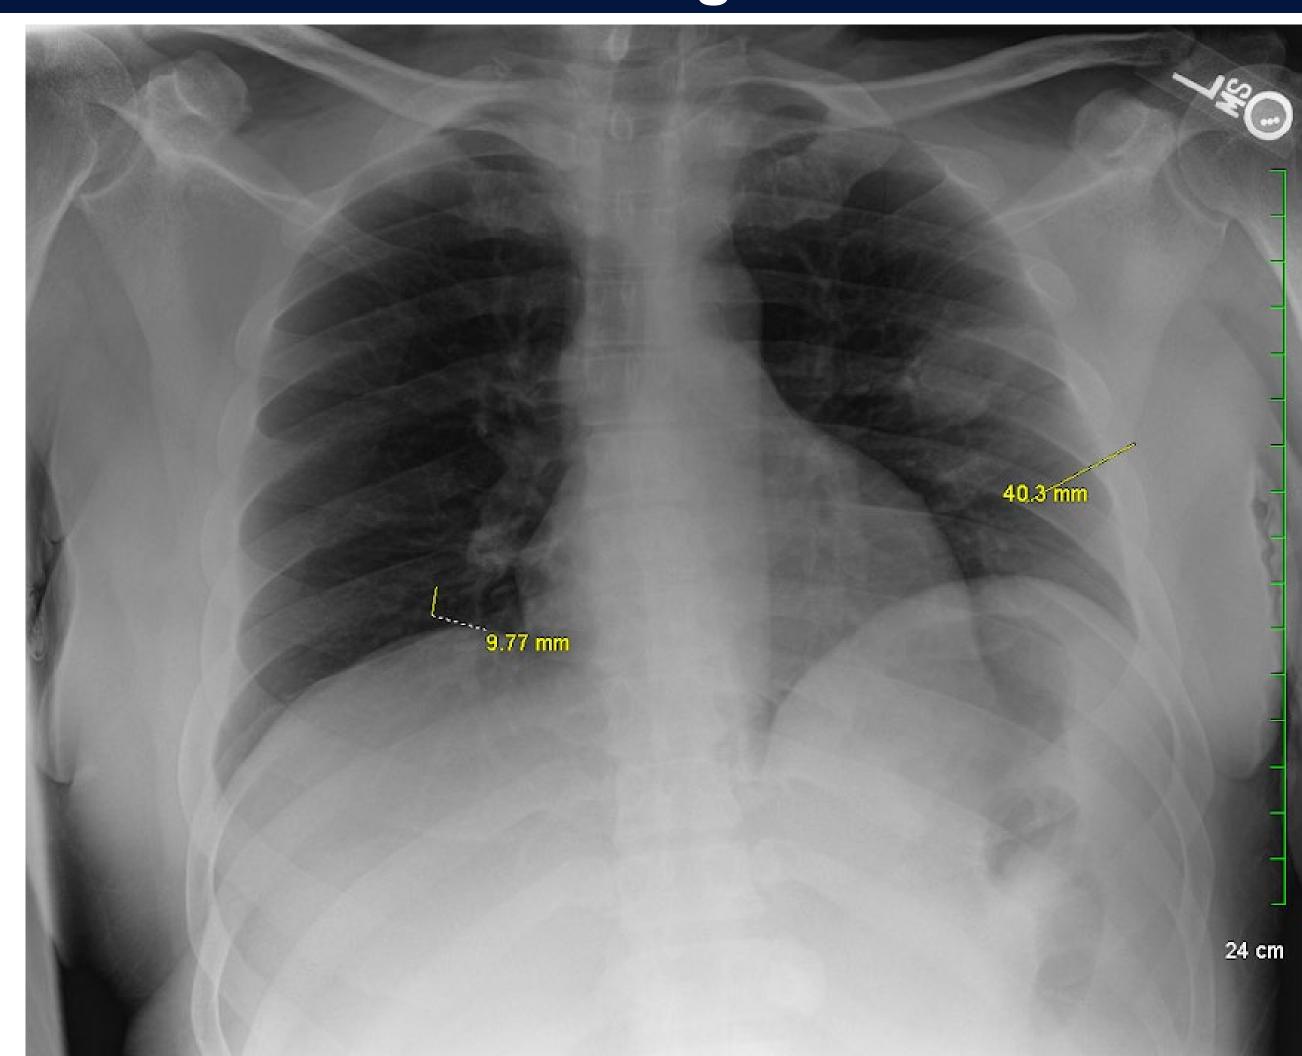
Chest x-ray on admission showing multiple lung lesions including 4 cm ovoid left midlung opacity and 1 cm nodularity involving the right lung base. Follow up imaging with Chest CT was recommended.
